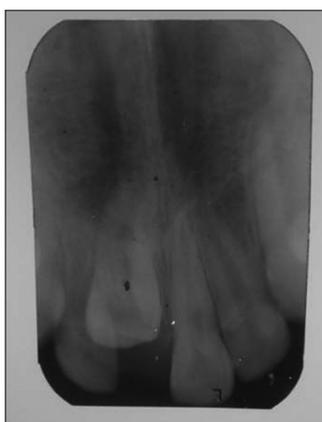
Radiograph showing impacted maxillary right central incisor
